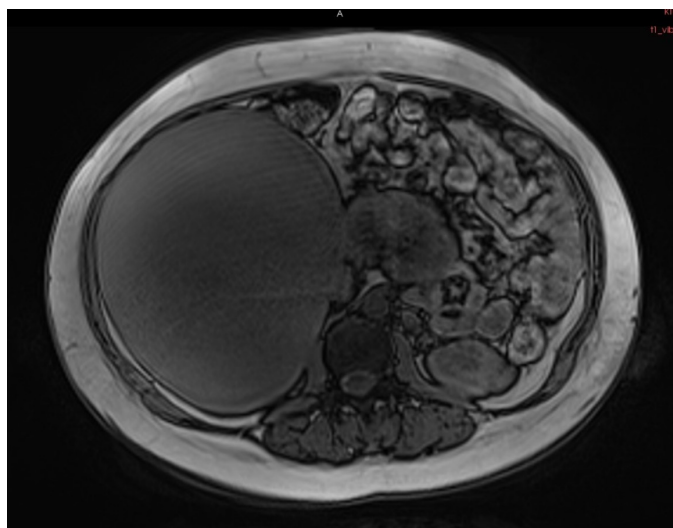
Axial image of the adrenal cyst, filling the right half of the abdomen (obtained from MRI studies)
